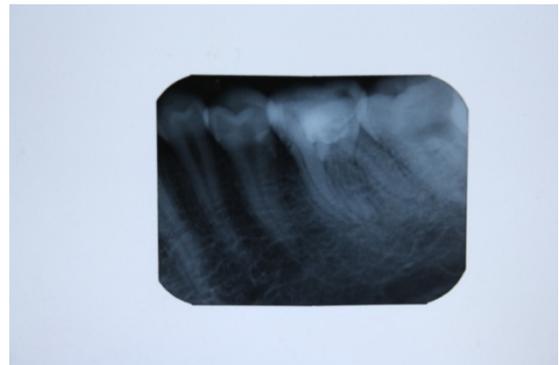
twenty-four months Follow-up IOPA radiograph with periapical healing
